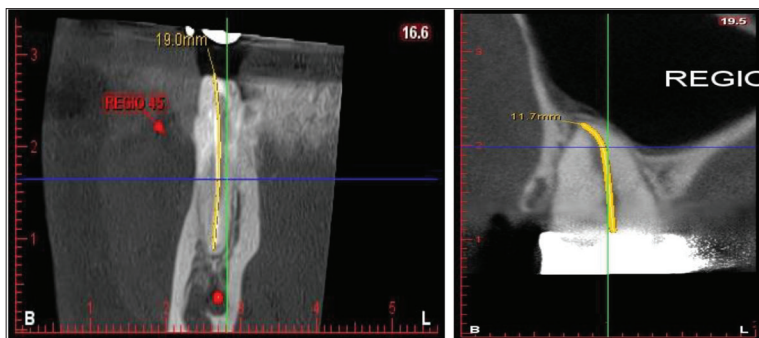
CBCT odontometry – Software compensation of the curved part of the canal
